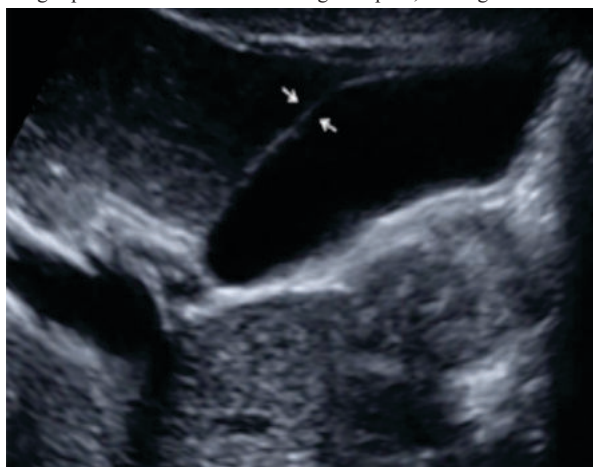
The thickness of the gallbladder wall is measured along the long axis of the ultrasound beam in an area where the gallbladder is contiguous with the liver.
